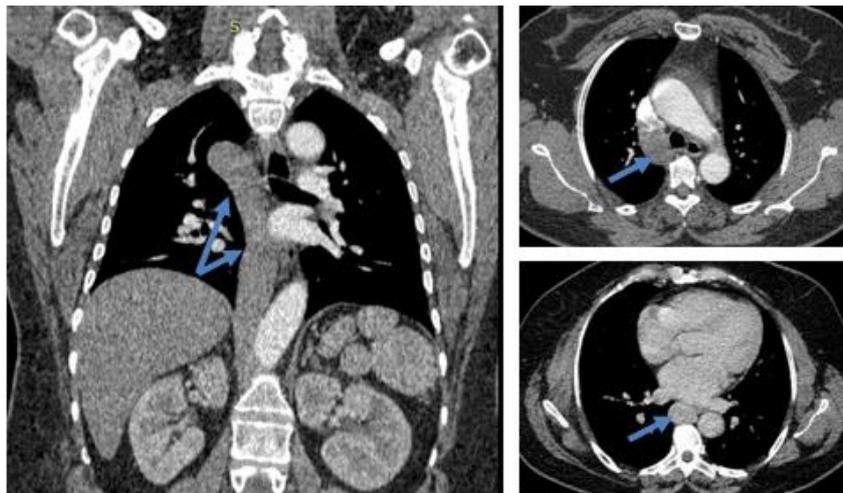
Contrast enhanced CT in coronal and axial sections displaying the agenesis of the IVC above the renal veins with dilatation of the azygos vein (blue arrow)
